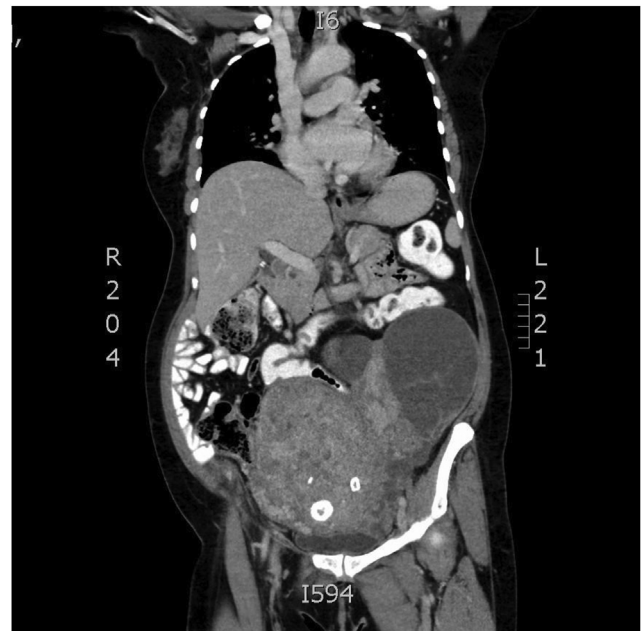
CT abdomen showing an enlarged uterus and a left adnexal cystic lesion.
